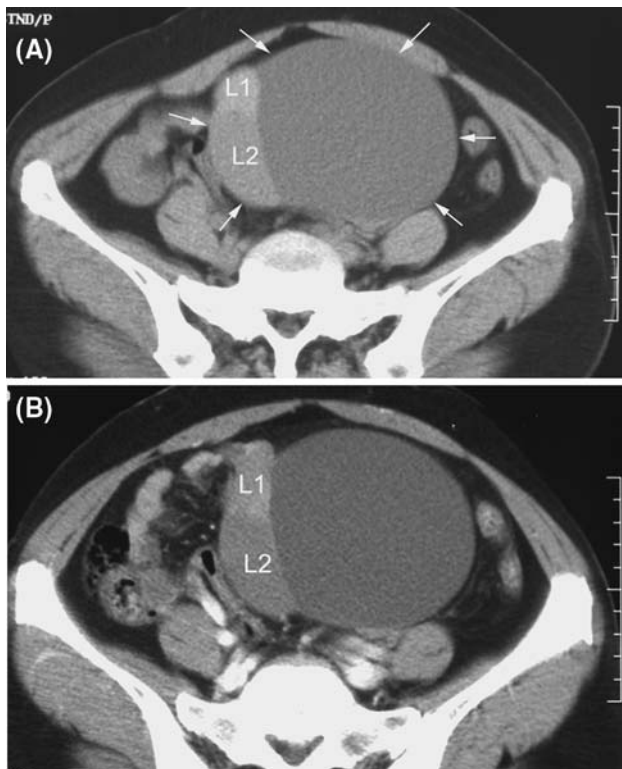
Struma ovarii in 51-year-old woman. A, Precontrast CT scan shows smooth marginated mass with multiple high attenuation lesions (L1, L2) in the mass (*arrows*), of 106.1 HU and 99.6 HU, respectively. B, Contrast-enhanced CT scan shows no cyst wall enhancement, nor are the lesions significantly enhanced
